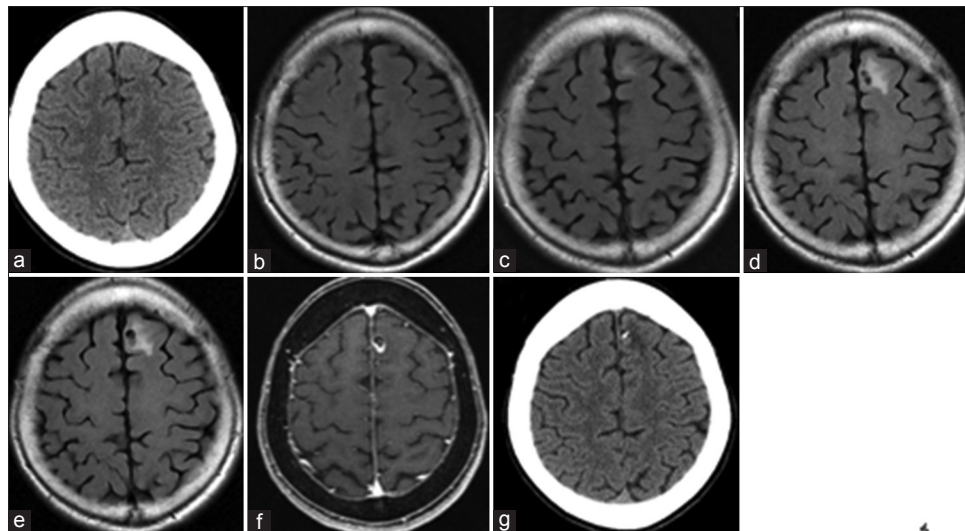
Preoperative magnetic resonance imaging scans done in June 2010, axial sections (a) and (b) with no visible lesion(s) noted within the brain parenchyma. A localized area of hyper-intensity was noted on the left frontal lobe in the fluid-attenuated inversion recovery sequence done in June 2012 as shown in (c) and an increase in the size was observed on the follow-up image as shown in (d) progressive increase in the size of lesion was seen on follow-up fluid-attenuated inversion recovery scan done in April 2013 as shown in (e) and the contrast enhanced T1 magnetic resonance imaging scan shown in (f) computed tomography scan done in April 2013 demonstrates calcification of the lesion as shown in (g)
